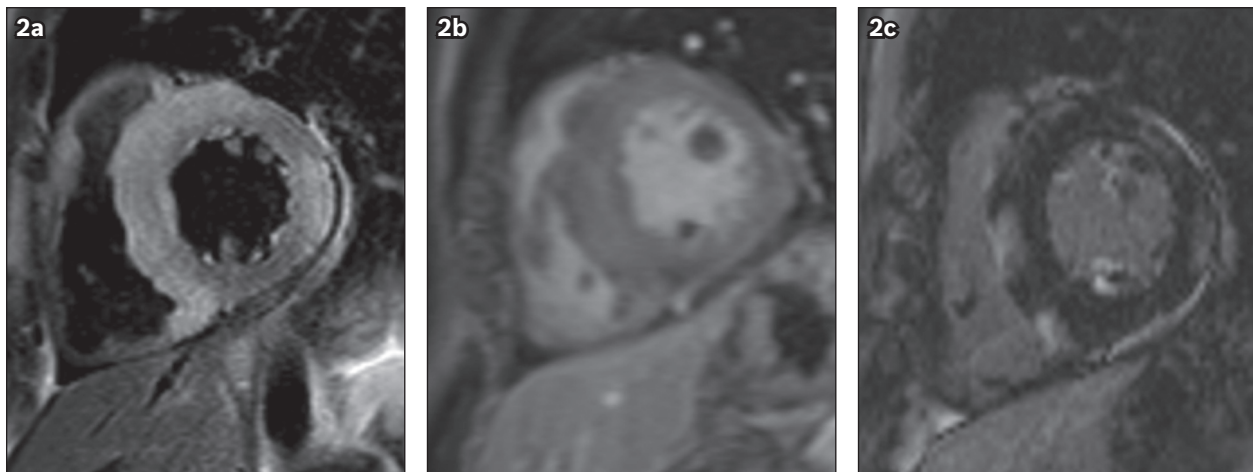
Short-axis (a) T2-W, (b) early contrast-enhanced and (c) late gadolinium enhancement (LGE) MR images.
